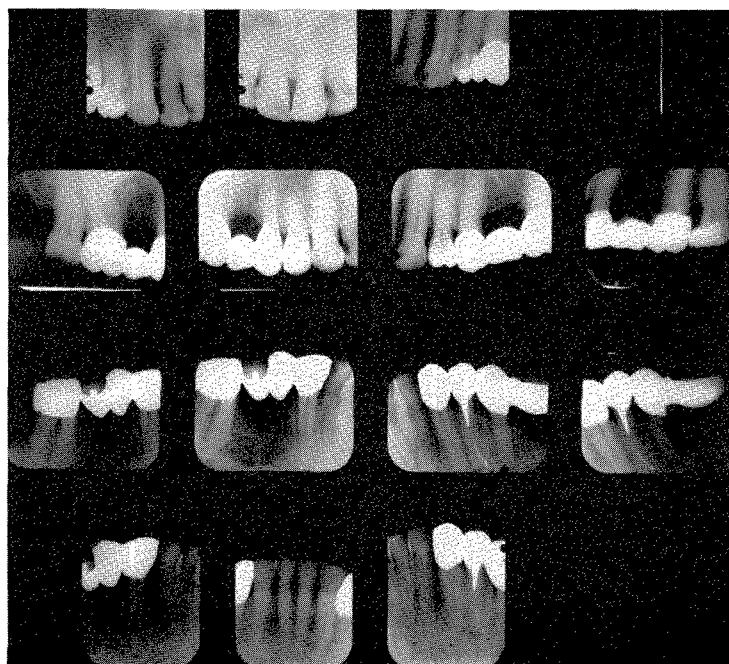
Roentgenograms taken in 1953 after insertion of the lower left cantilever. There are three abutment teeth.
